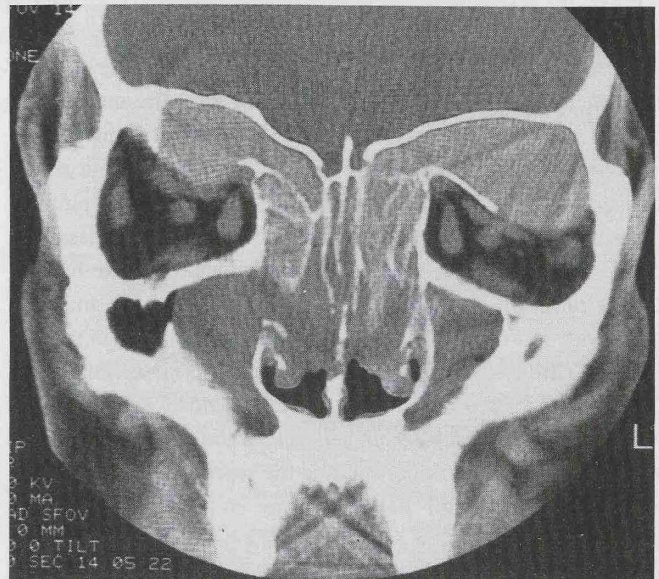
Case 2: Coronal CT scan showing the large extensions of the ethmoids filled with hyperdense tumour, displacing the roofs of the orbits, as well as the superior straight and oblique muscles of the eyeballs.
